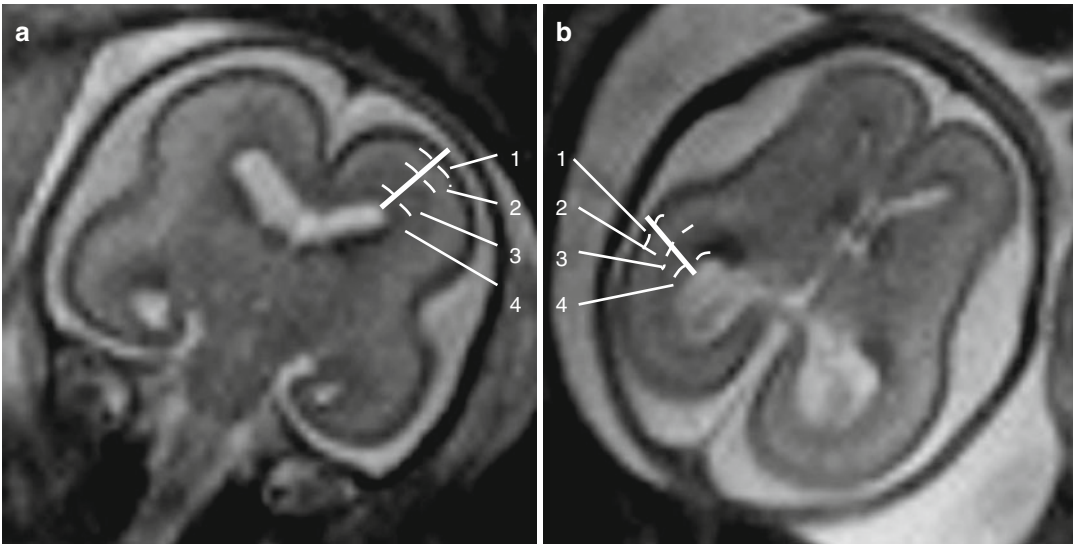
Multilayered appearance of the developing nervous system at GW 24. (a, b) Coronal (a) and axial (b) T2-weighted images (TR/TE ∞ /95 ms): from the surface
